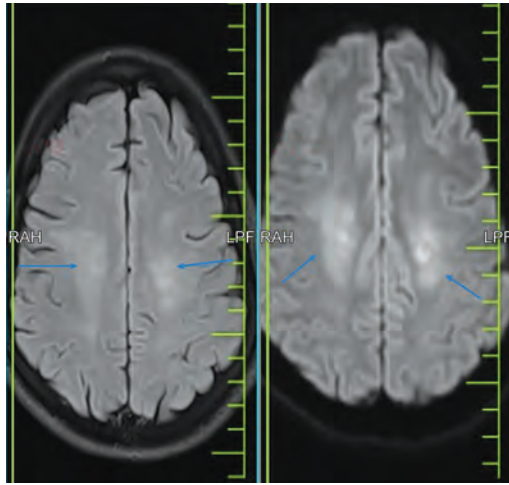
Showing hyperintensities in the cerebral white matter (extrapontine) on FLAIR and DWI images
